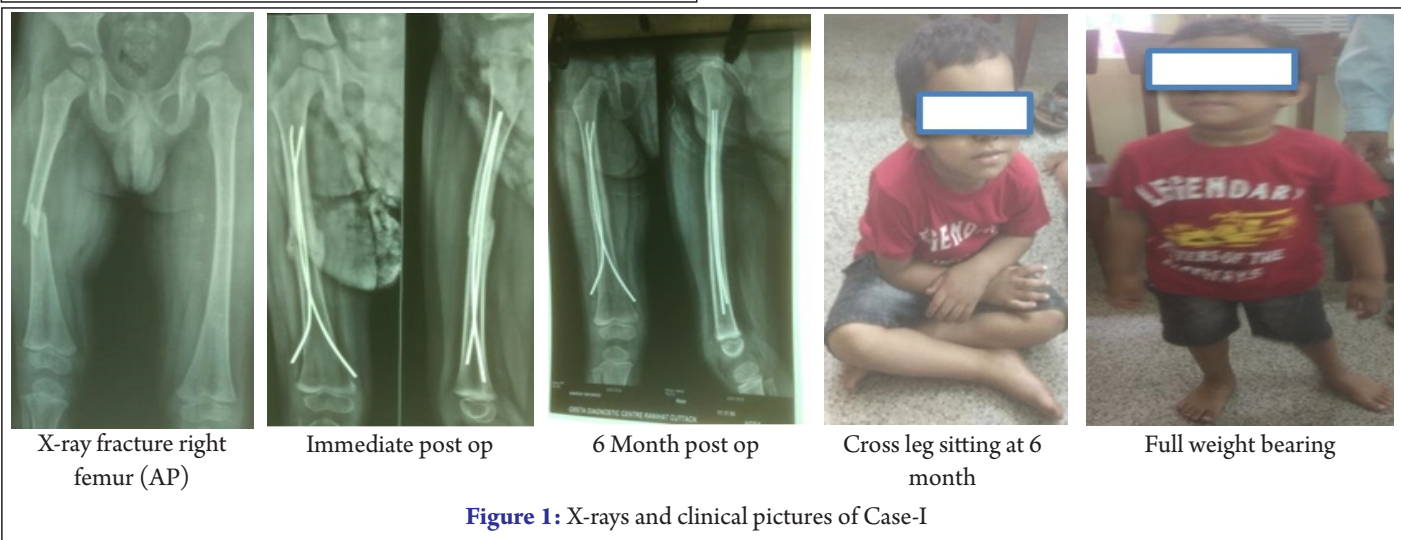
X-rays and clinical pictures of Case-I
